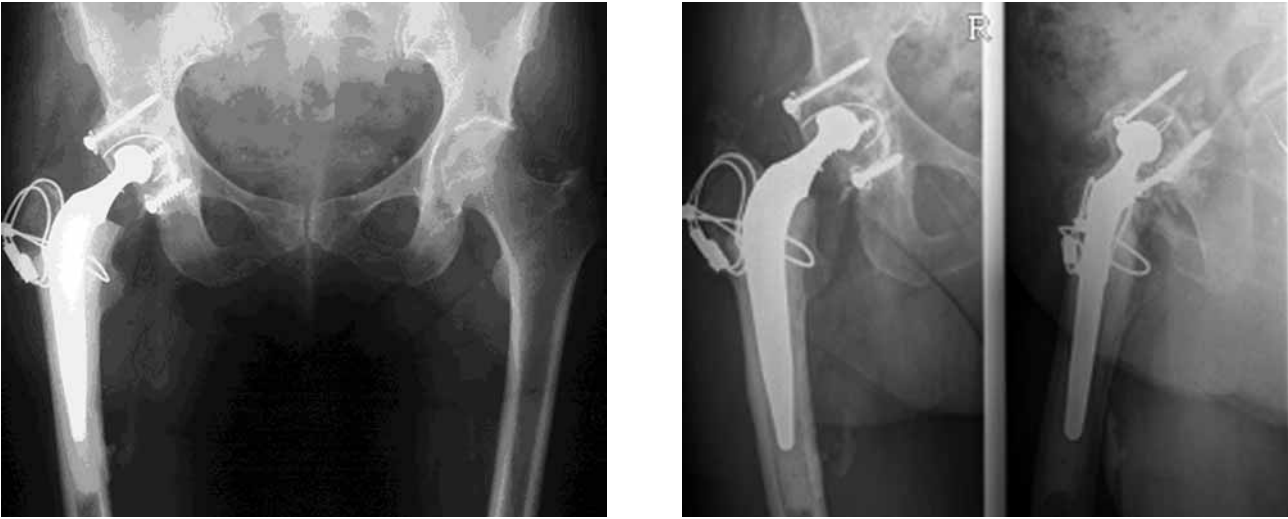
Initial postoperative radiograph (left) and follow-up radiograph more than 15 years after surgery (right) of a flanged cup fixed with hydraulic pressurisation cementing technique.
